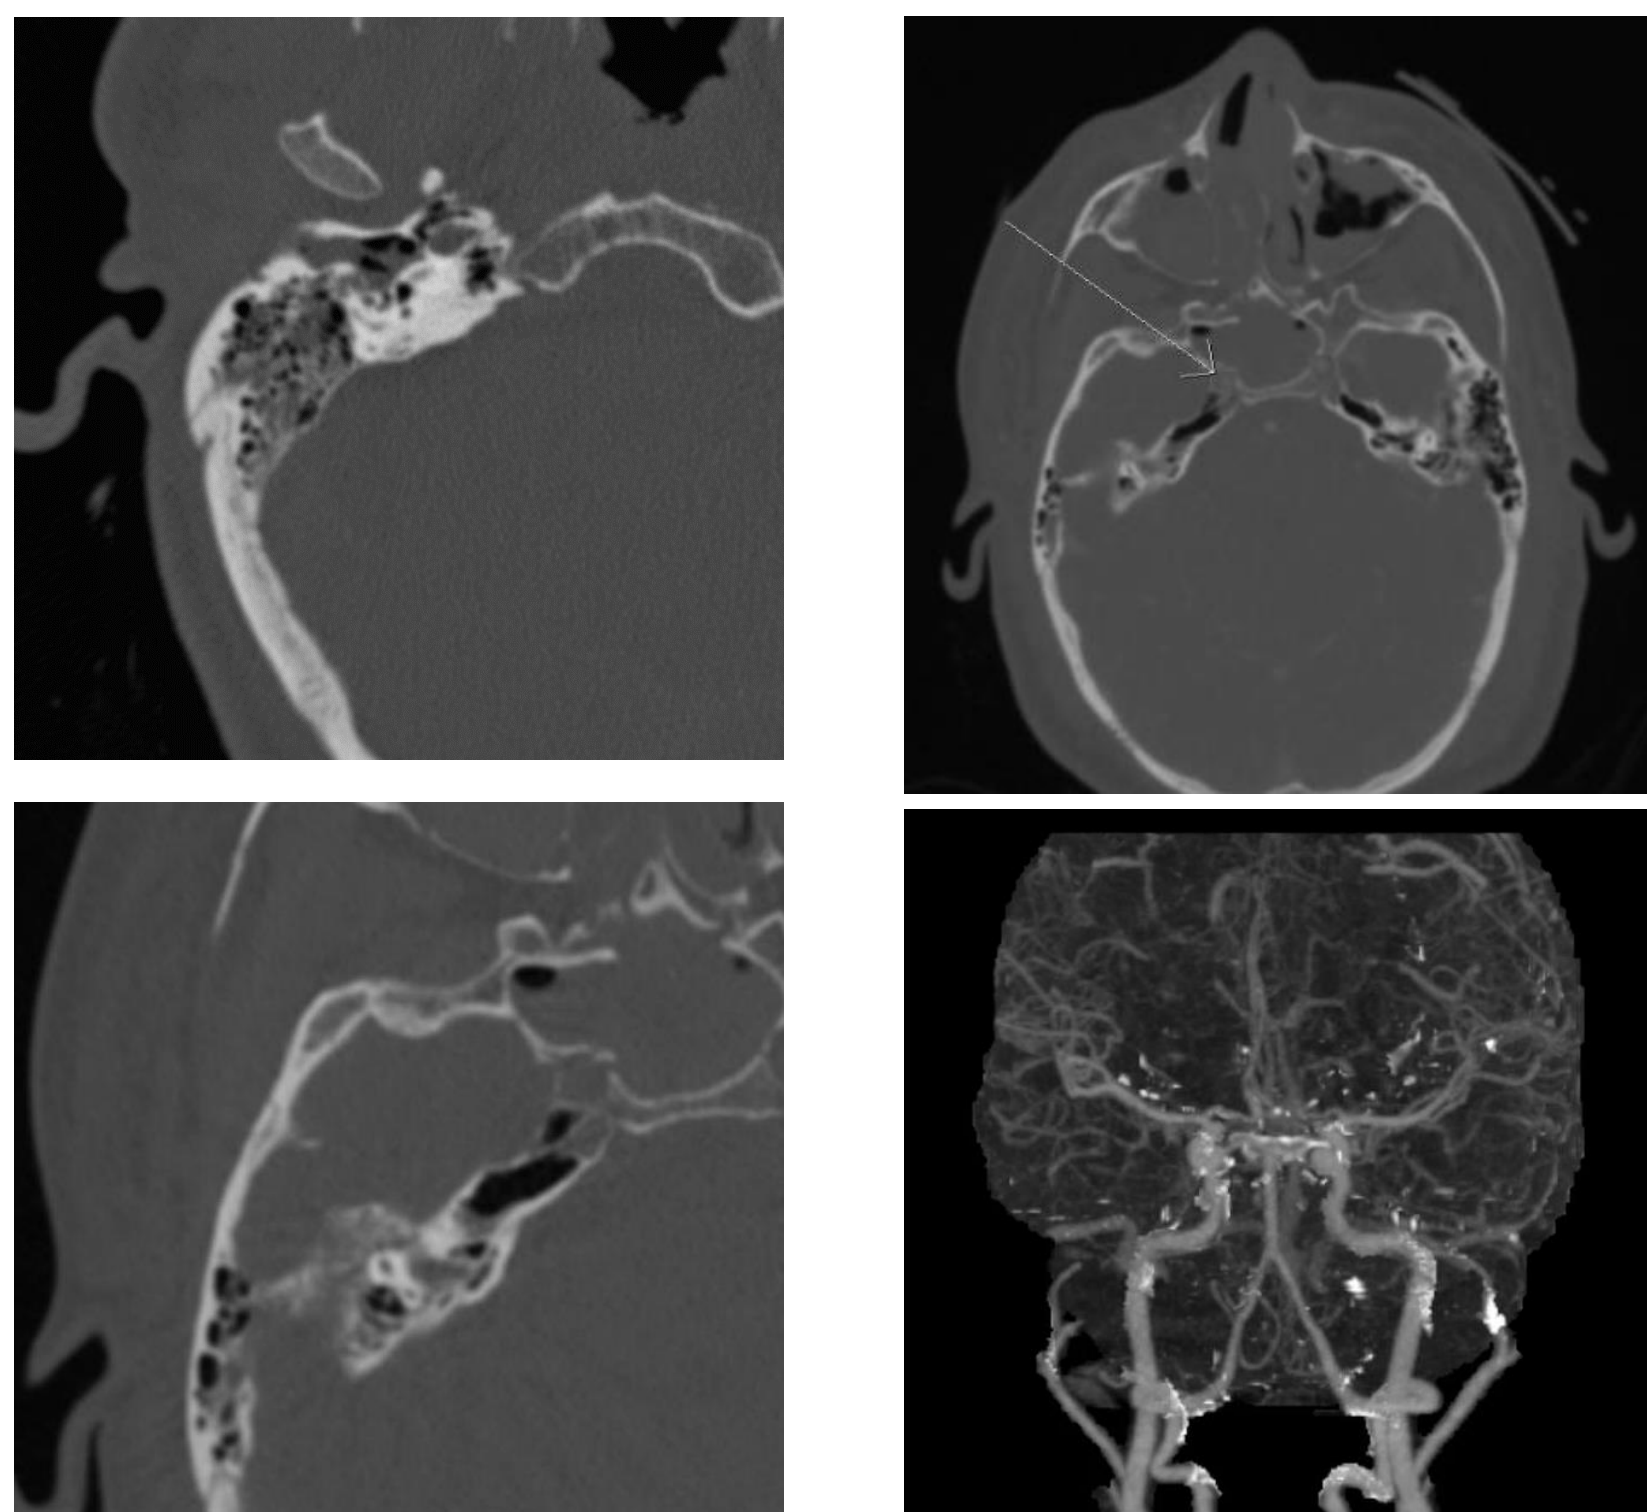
Right longitudinal temporal bone fracture with small dissection of the right ICA on CTA
